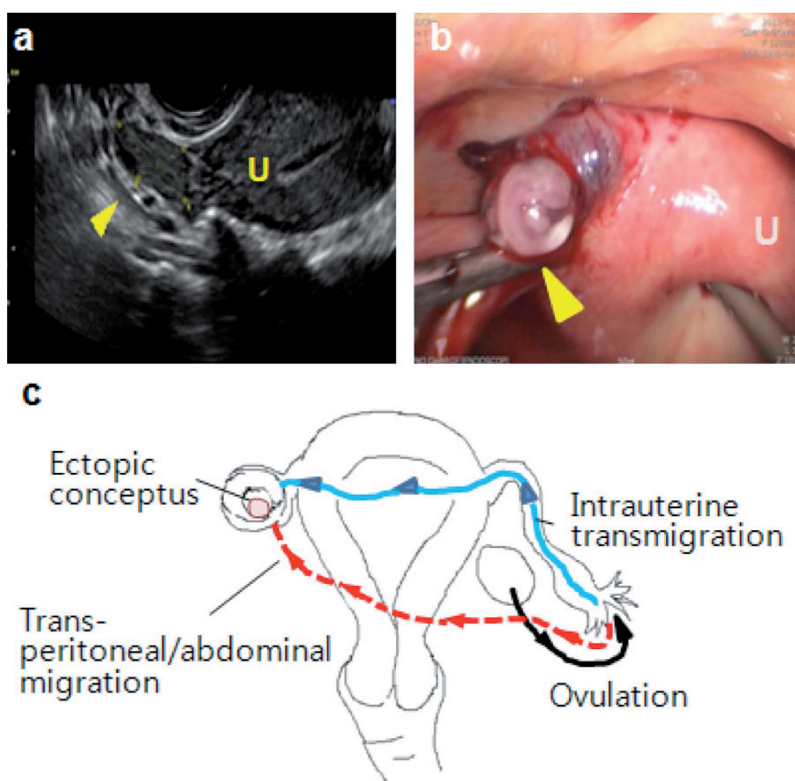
(a) Ultrasonogram of ectopic pregnancy (axial view of uterus). (b). Laparoscopic finding of ectopic pregnancy. (c) Intrauterine and transperitoneal/ transabdominal migration of fertilized egg. U: uterus. Arrow: ectopic conceptus.
